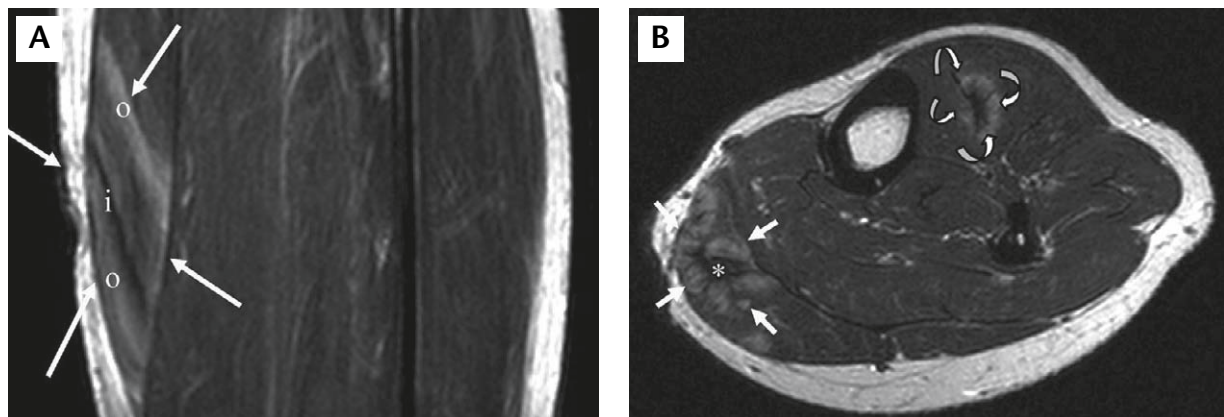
Magnetic resonance imaging of the left leg; T1-weighted image with intravenous administration of contrast agent (Gd-DTPA). (A) Coronal scan through the calf muscles. Note the well-defined striated mass (arrows) with contrast-enhanced zones in the outer part (o) of the gastrocnemius muscle and zones of low signal intensity in the inner part (i). (B) Axial scan through the middle third of the lower leg. Note the corresponding mass lesion (short arrows) has a "dark star" low signal intensity at the centrum (*) and heterogeneous contrast-enhanced zones at the periphery. Note that another lesion (curved arrows) is located in the tibialis anterior muscle.
